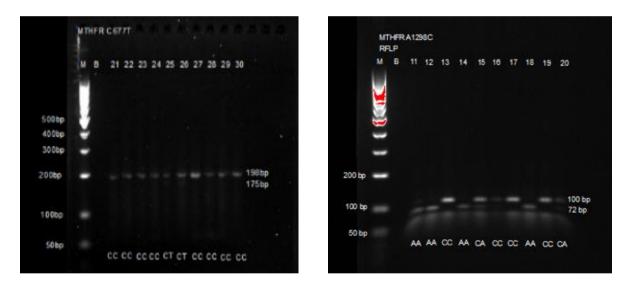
(Left to Right) Agarose gel of MTHFR C677T polymorphism PCR-RFLP product, digestion result (CC: 198 bp; CT: 198 bp, 175 bp; TT: 175 bp), B: Blank, M: Marker, (b) Al298C RFLP result, M: Mark, B: Blank, digestion result (AA: 72 bp; AC: 100 bp and 72 bp; CC: 100 bp)
